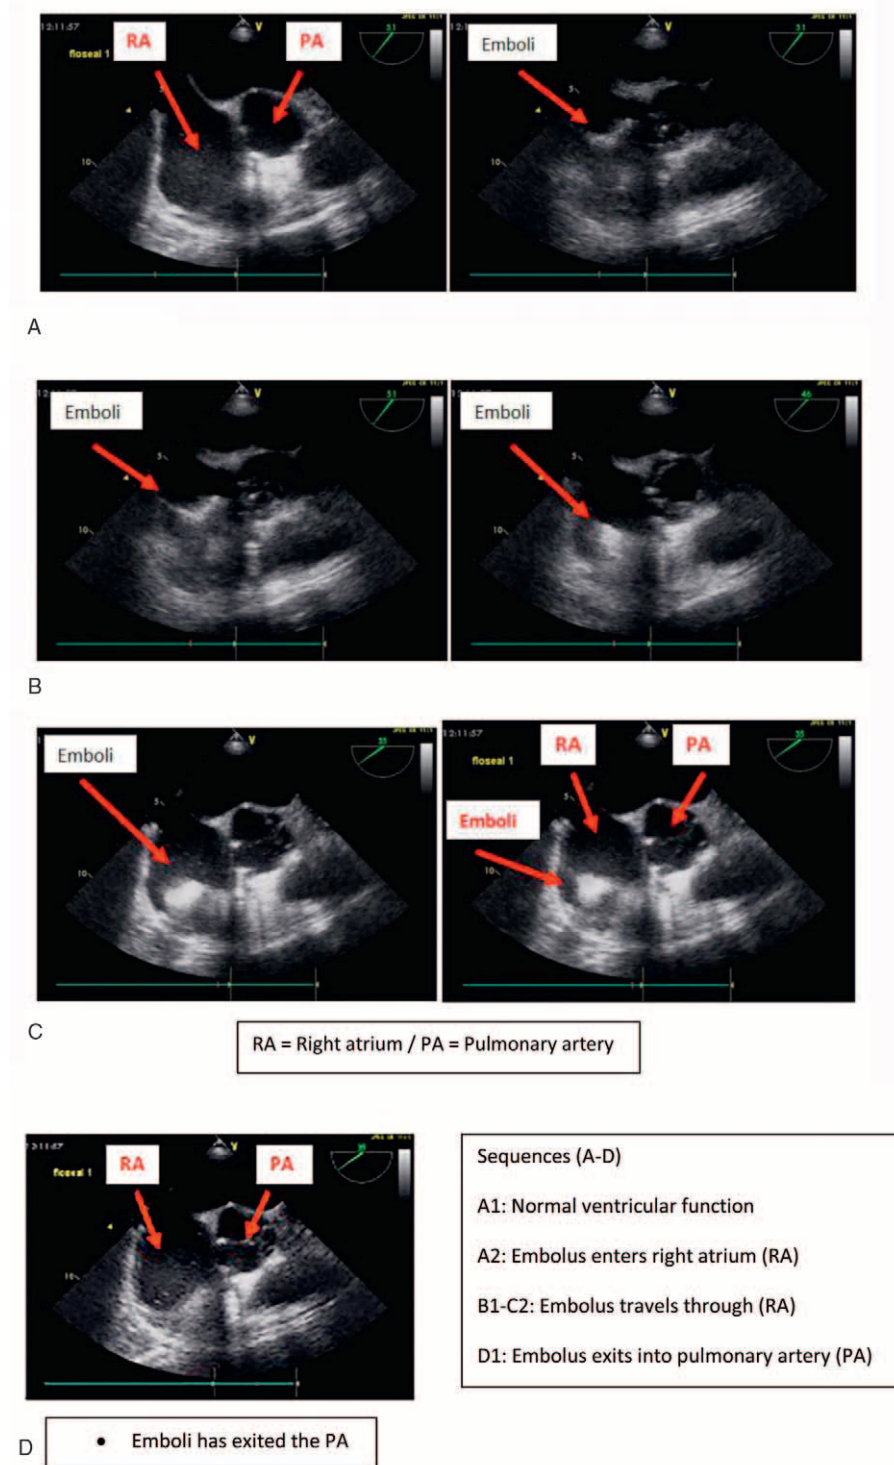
Depicts a sequence of transesophageal echocardiogram images showing an embolus entering the heart and exiting into the pulmonary vasculature.
